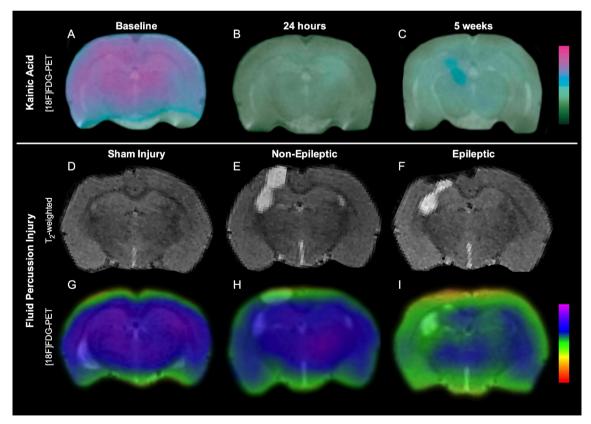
Volumetric and [18F]FDG–positron emission tomography (PET) changes in kainic acid model of temporal lobe epilepsy and fluid percussion injury model of traumatic brain injury (TBI). There is persistent hypometabolism, and progressive degeneration after kainic acid-induced
